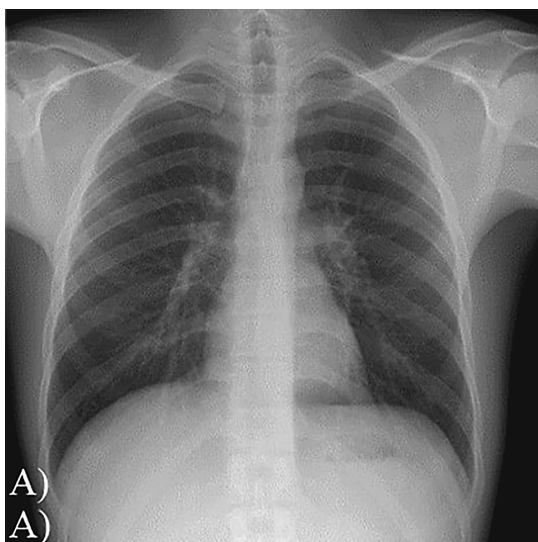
Chest X-ray: a — from 18.09; b — from 29.09
